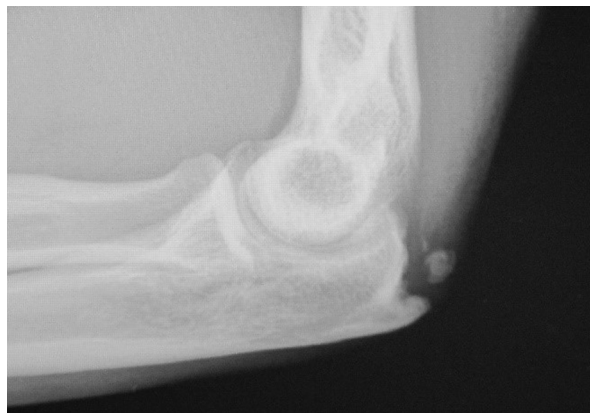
A lateral radiograph shows a representative olecranon spur and spur fragment.
